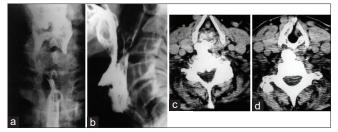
Case 1: (a and b) Barium swallow study in anteroposterior (a) and lateral (b) views: Interruption of the column of contrast at the level of the osteophyte. (c and d) CT scan, axial section at C4 (c) and C5 (d): Large anterior osteophyte
